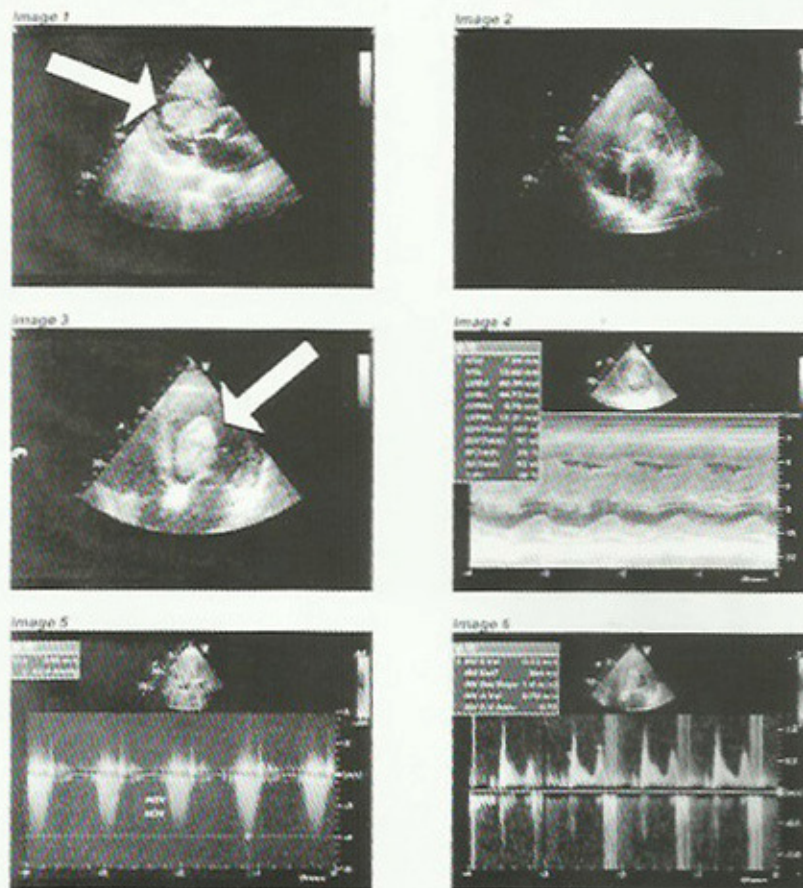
Echocardiography shows left ventricular myxoma.
